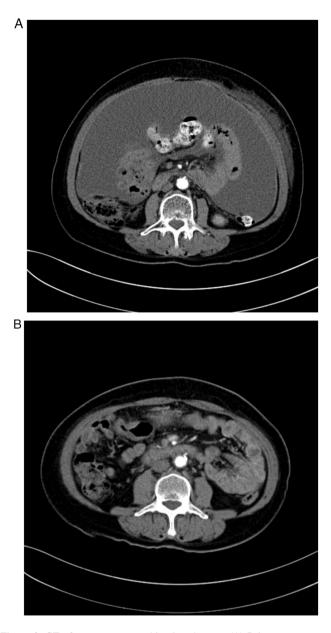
CT of response to combination therapy. (A) Prior to treatment, multiple metastases occurred in the peritoneum and seroperitoneum. (B) After the treatment, peritoneal metastasis and seroperitoneum had disappeared.
